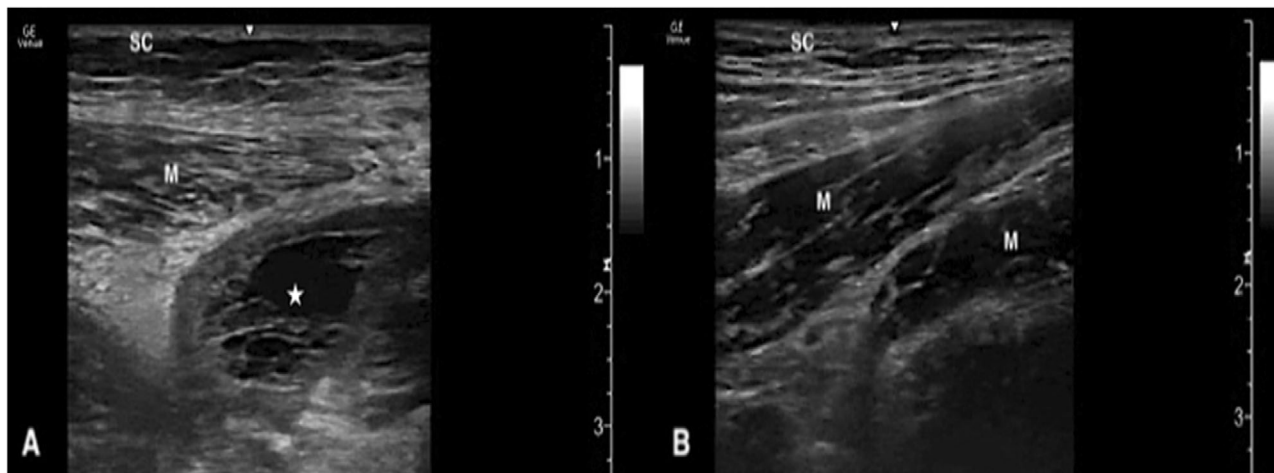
Point-of-care ultrasound of the affected left lateral thigh (A) and the unaffected right lateral thigh (B) in the sagittal plane. There is a large hypoechoic fluid collection (star) within the muscle, representing an intramuscular abscess. SC, subcutaneous tissue; M, muscle
